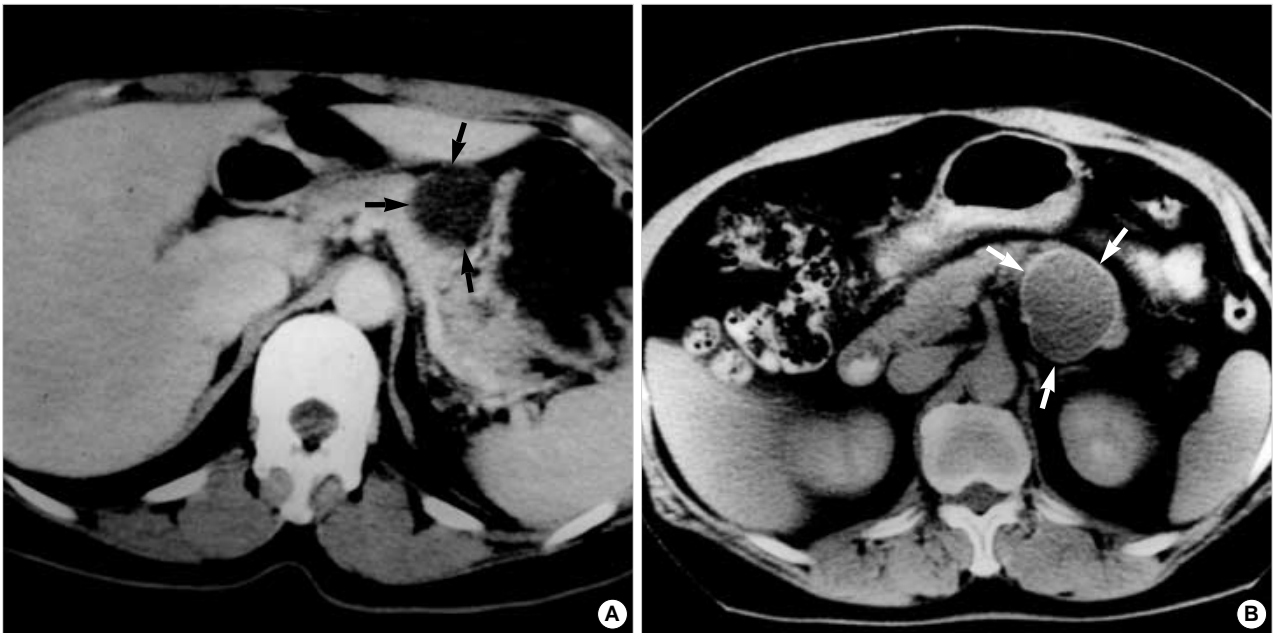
(A) Abdominal computed tomography (CT) of case 1 showed a homogeneous, $2.5 \times 3 \times 3$ cm sized, unilocular cystic mass in the pancreatic body that was hypoattenuating relative to the adjacent pancreatic parenchyma, without septation or enhanced solid portion (arrows). (B) Abdominal CT of case 2 showed a $4.5 \times 5 \times 5$ cm sized, unilocular cystic mass in the pancreatic tail without septation or solid portion (arrows).
